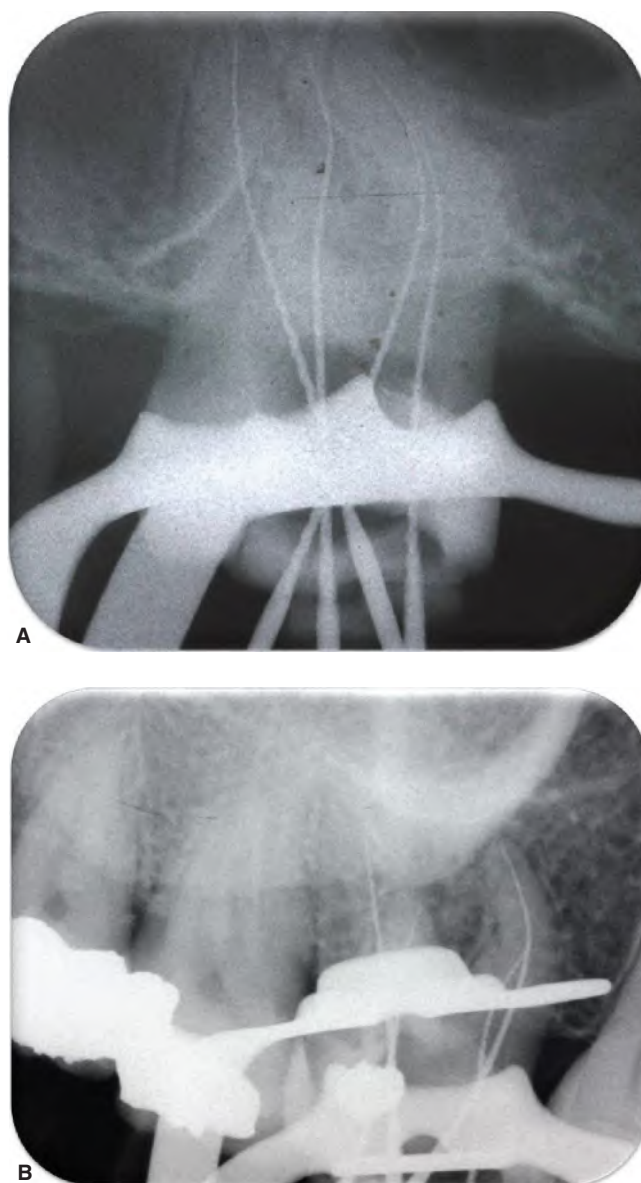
A & B. Radiographs demonstrating different locations and angles of confluence.
